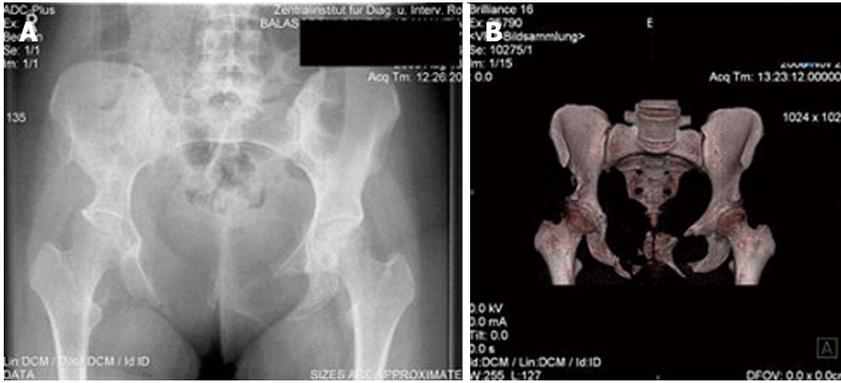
Case example: X-ray (A) and computed tomography scan (B), of a 26 years old female, with vanishing bone disease of the pelvis. She presented with mild groin pain without any further symptoms.
